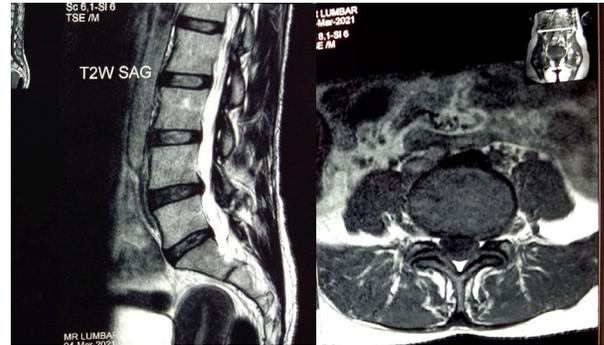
T2W Sagittal and Axial view of MRI Lumbosacral
